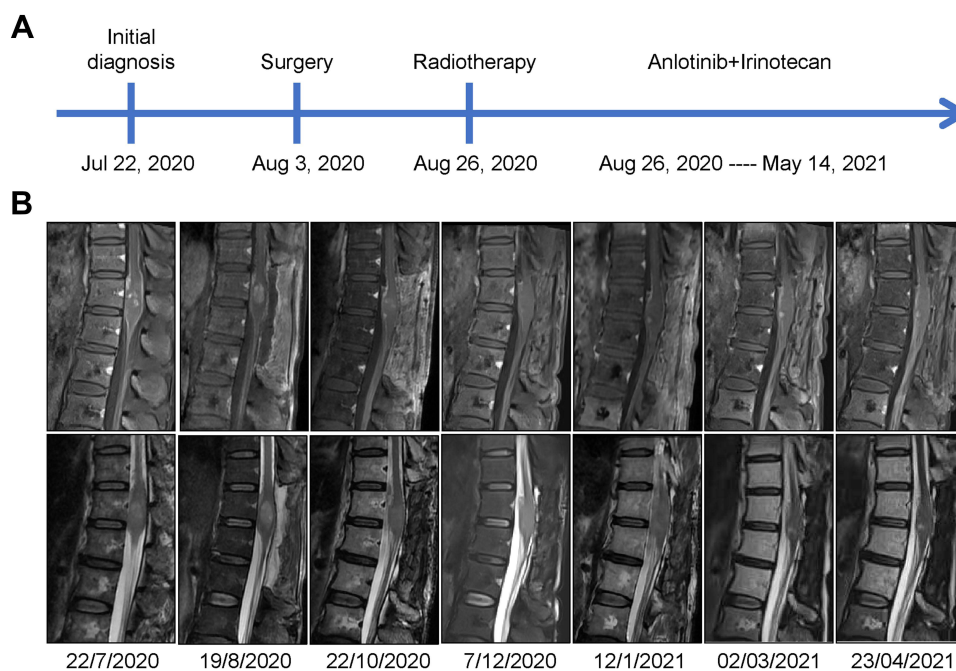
Timeline of treatment and MRI responses. (A) Timeline of the patient's treatment. (B) MRI images of the patient at different times.
